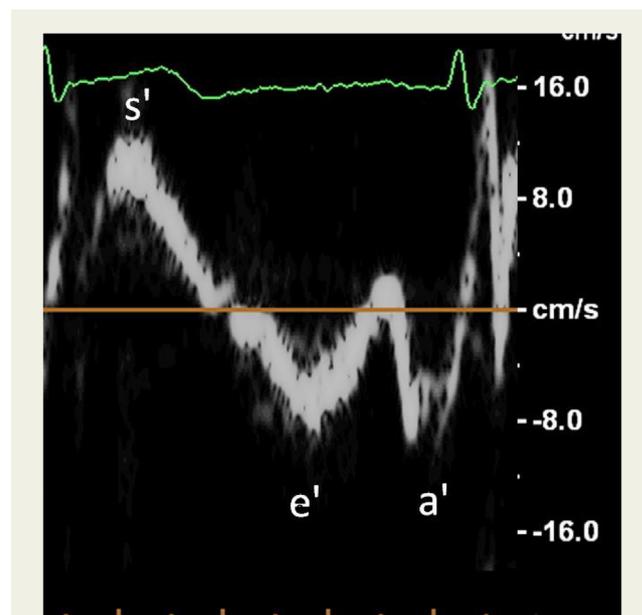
Tissue Doppler image of lateral tricuspid annulus demonstrating early (e') and late (a') diastolic waves and peak systolic (s') wave.
